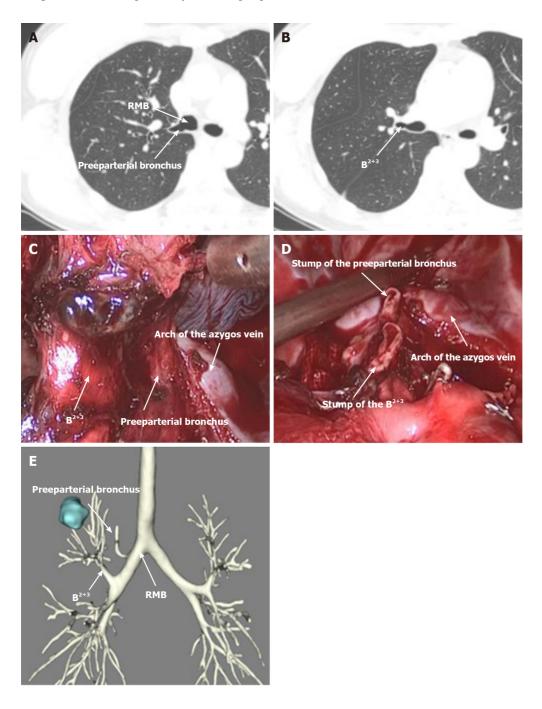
Abnormal right preeparterial bronchus. A: Right preeparterial bronchus arose from right main bronchus alone in thin-section computed tomography; B: B²⁺³ arose below right preeparterial bronchus from right main bronchus; C: Right preeparterial bronchus and B²⁺³ under thoracoscope; D: Stump of right preeparterial bronchus after stapling and B²⁺³ under thoracoscope; E: Three-dimensional reconstruction of trachea and bronchus.
